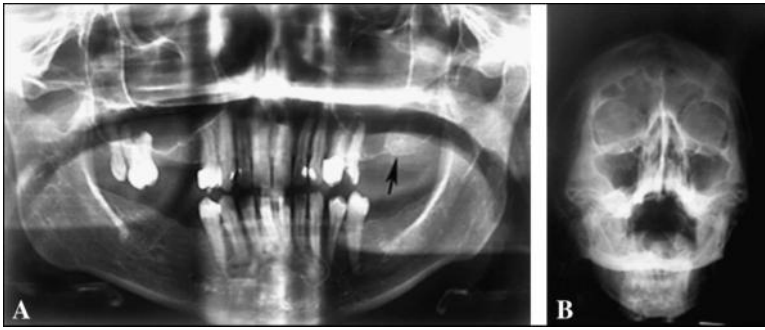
A, Panoramic radiography shows dense bone opacification at the site of the extracted tooth 27 (arrow); B, Water's view radiography shows the absence of maxillary sinus pathoses.
